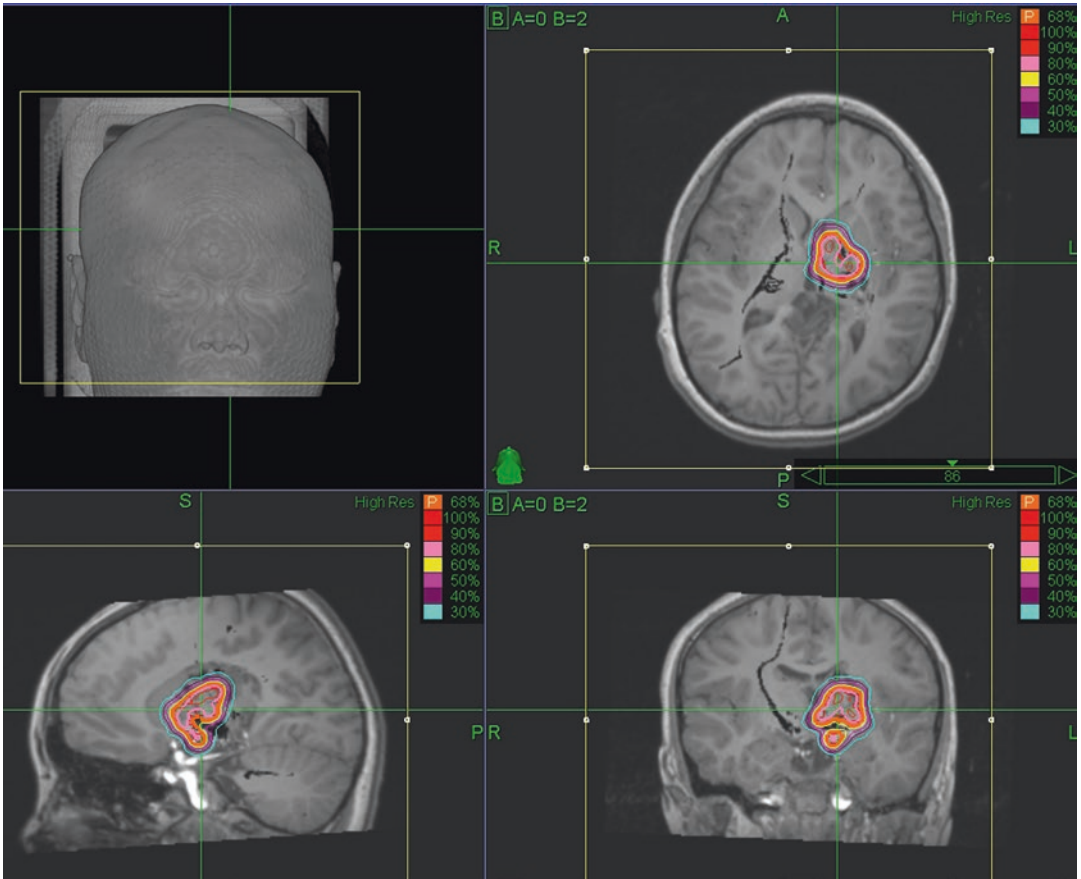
The exact location of corticospinal tract, especially in deep white matter, could not be identified using conventional sequences such as enhanced CT or T1-weighted MR imaging studies. The fused DTI MR
